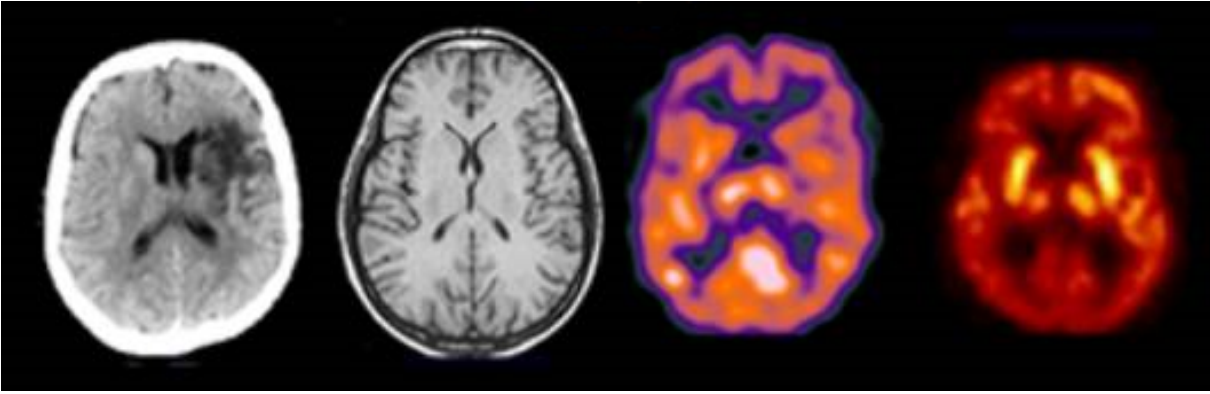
Transaxial slice of the human brain acquired with different imaging modalities. From left to right: X-ray Computed Tomography, Magnetic Resonance Imaging, Single-Photon Emission Computed Tomography and Positron Emission Tomography [15].
